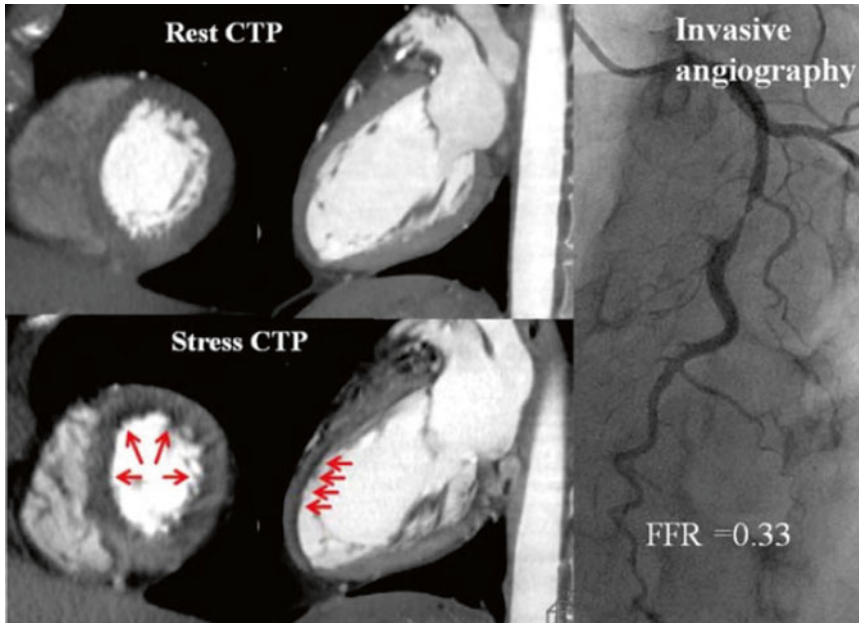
CT perfusion imaging and invasive angiography. Stress perfusion defects are demonstrated on CT in the mid and distal anterior wall corresponding to a severe stenosis in the mid LAD associated with an FFR of 0.33 (Adapted from Ko BS, Cameron JD, Meredith IT et al.
